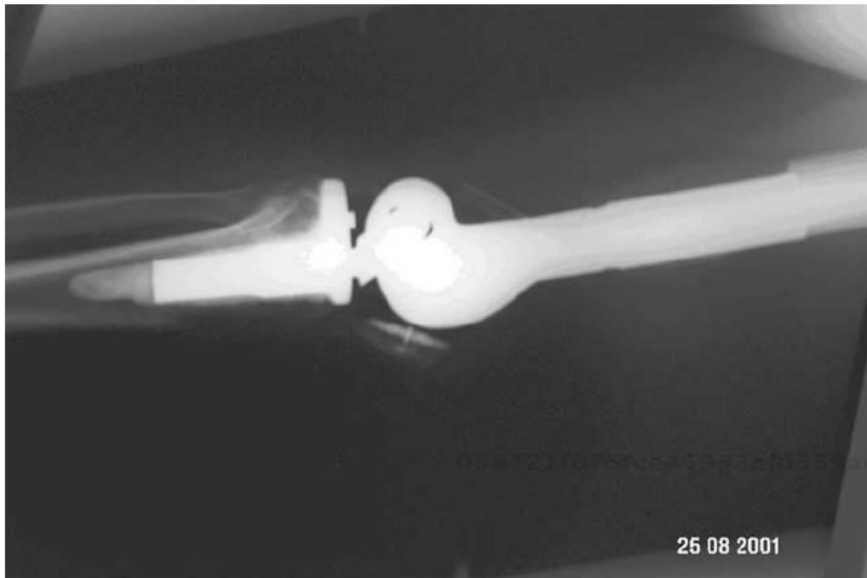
X-ray of a constrained modular knee replacement with distal femur. The distal femoral replacement is longer than that shown in Fig. 6.11. This demonstrates a clear advantage of the modular systems. Courtesy of Carlos Cuervo-Lozano M.D.
